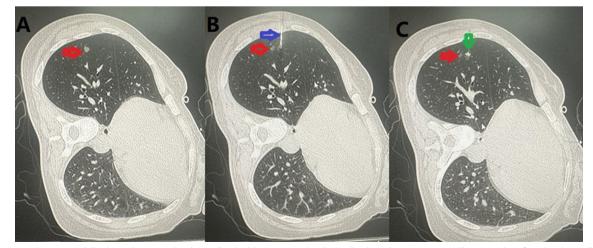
Localization nodule: the red arrow; 4-hook needle: the blue arrow; 4-hook needle claw: the green arrow. The procedure for 4-hook needle localization nodule: A: patient is positioned appropriately, and the location of the nodule is determined by CT scan. B: a puncture needle is used for target nodule localization; C: the 4-hook needle claw is released and fixed to lung tissue
